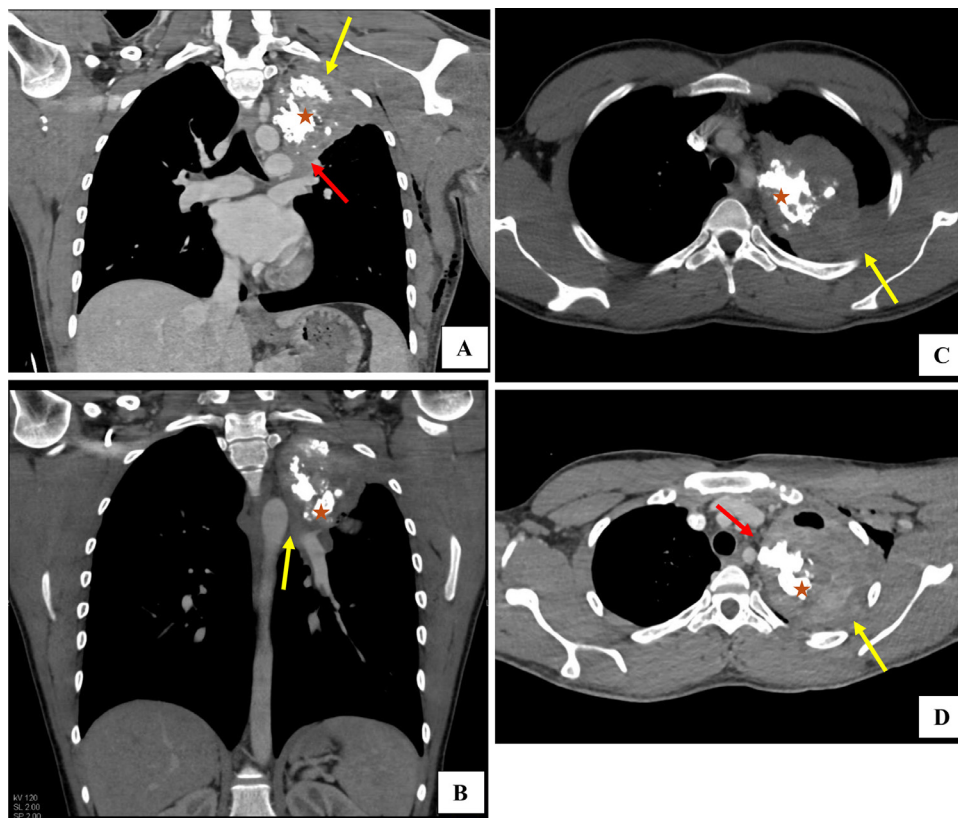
A 22-year-old male presenting with chest pain and shortness of breath during training. Coronal (A and B) and axial (C and D) CT scan shows a large lobulated soft tissue mass with coarse calcifications (orange star) in the left lung apex. The mass extends to the apical (A – yellow arrow) and posterior chest wall (C, D – yellow arrow), without invasion or significant mass effect on surrounding structures. Inferiorly, it extends to the left hilum and along the oblique fissure (A – red arrow). There is preserved fat plane between the mass and the aortic arch (B – yellow arrow). Left hilar lymphadenopathy is also seen (D – red arrow).
